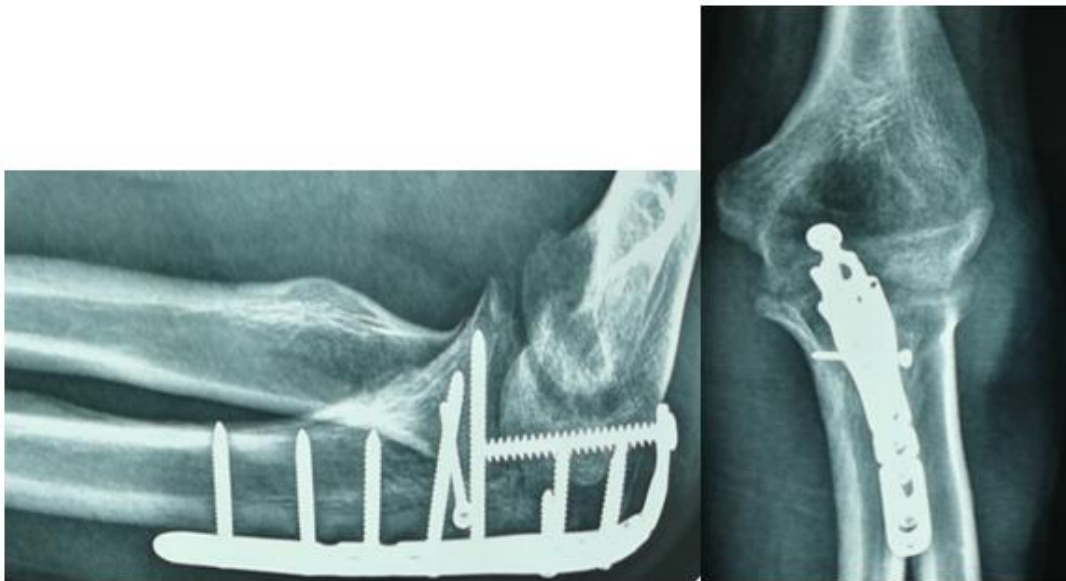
Follow-up X-ray at 12 weeks
